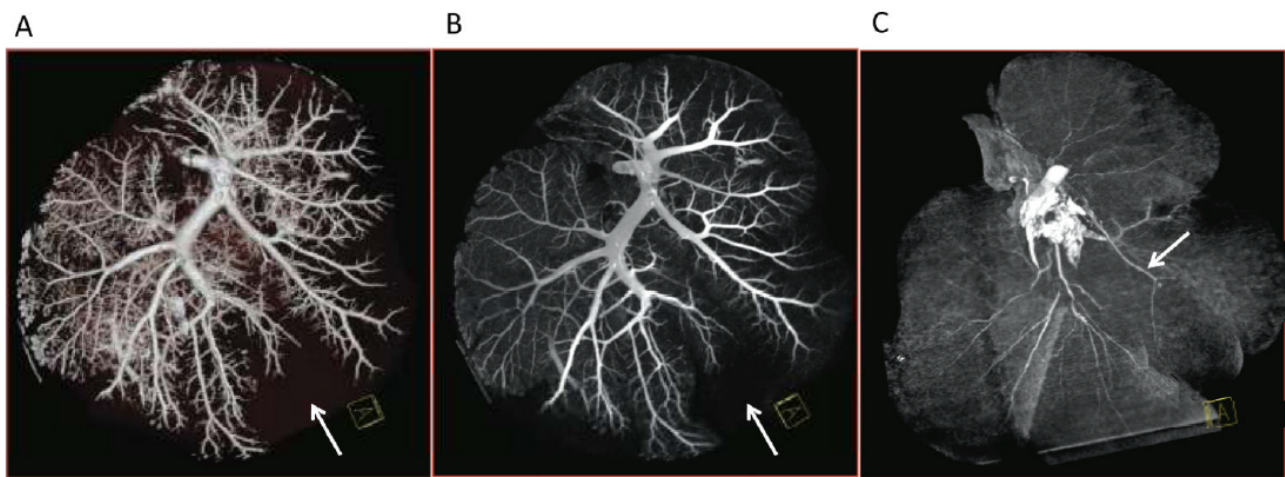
Maximum intensity projection images of hepatic vasculature obtained using a contrast-enhanced CT angiogram. Branching of the portal vein (A in 3D and B 2D with contrast enhancement, arrow indicates the gallbladder covering the vasculature) and hepatic artery (C, 2D with contrast enhancement, arrow indicates cystic artery approaching the gallbladder) are shown.²⁷
